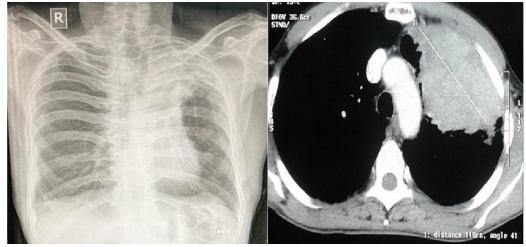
Chest X-ray (CXR) showing a persistent homogeneous opacity in the left upper zone. Figure 4: Contrast-enhanced computed tomography (CECT) of the chest demonstrating a mass lesion in the left upper lobe, with encroachment on the left main stem bronchus
